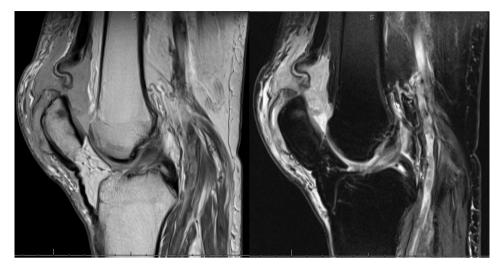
Sagittal MRI sequences demonstrating a quadriceps tendon rupture in a native knee. MRI, magnetic resonance imaging.
